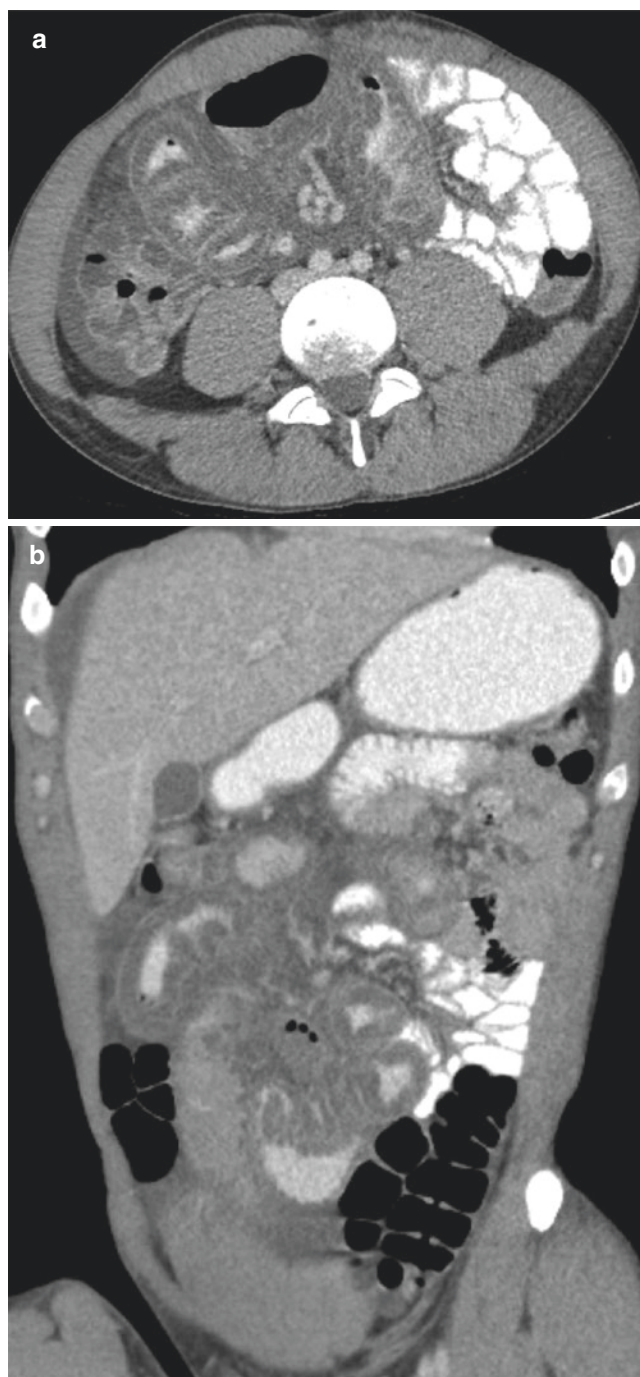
Infectious gastroenteritis. Axial (a) and coronal (b) CT images of infectious gastroenteritis, with diffuse nonspecific markedly thickened, low attenuation small bowel loops with mesenteric fat inflammatory changes
